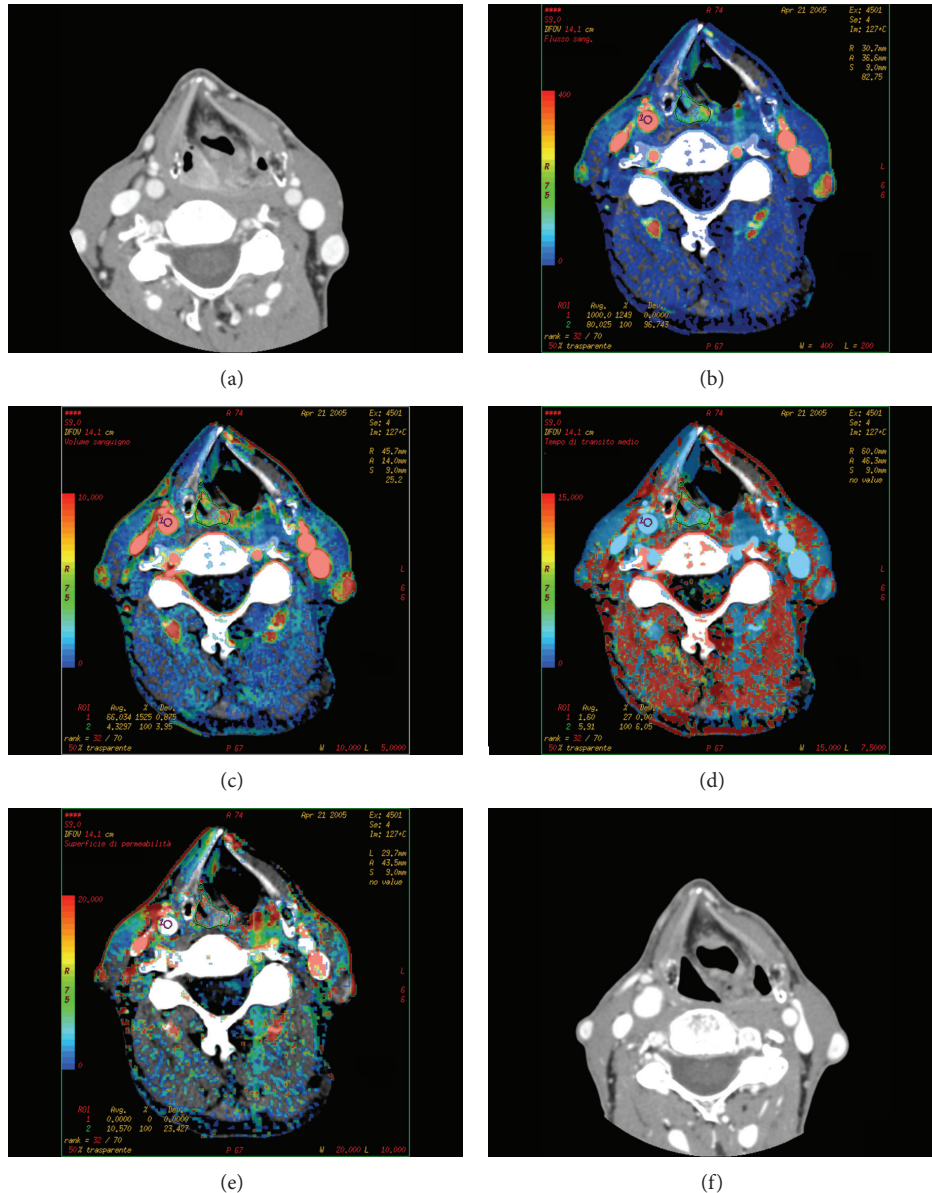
Squamous cell carcinoma of hypopharynx in a responder patient: CT scan (a) obtained before chemotherapy shows the lesion involving the right piriform sinus. On the same section, functional maps of BF (b), BV (c), MTT (d), and PS (e) are automatically generated by the software, showing the values calculated in each pixel of the image in a color scale. CT scan obtained in the same patient after chemotherapy and radiotherapy showing a complete disappearance of the tumour (f).
